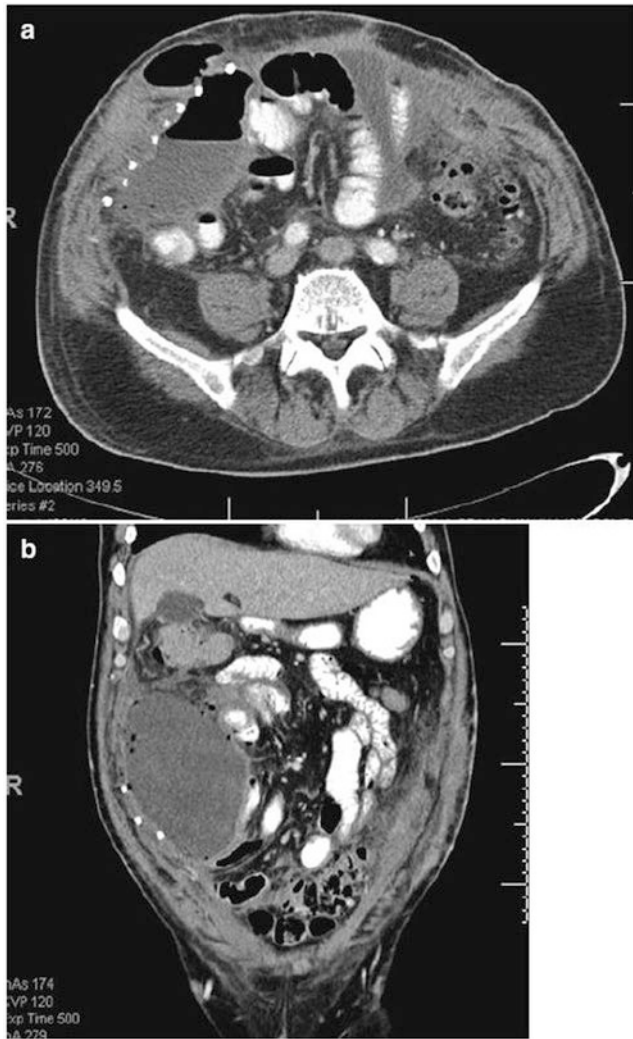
(a, b) Large fluid collection on either side of the mesh with radiopaque tacks indicating the location of the mesh. Air within the collection suggests that the collection is likely an abscess. CT-guided drainage of the collection will be necessary to drain the abscess and obtain fluid for microbiologic evaluation. Lightweight polypropylene mesh can often be salvaged with drainage and long-term antibiotics
